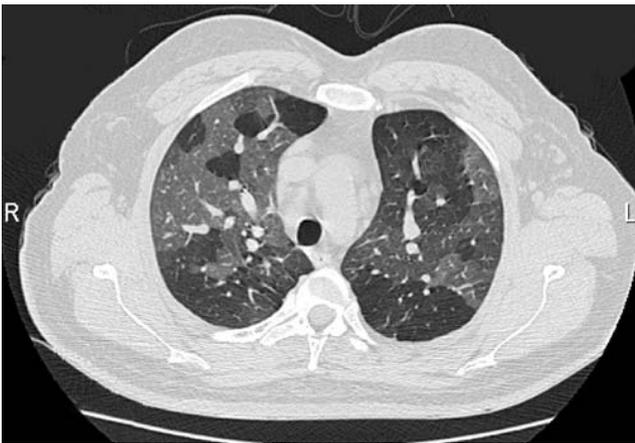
High-resolution computed tomography (HRCT) of a 43-year-old man exposed to mustard gas 20 years earlier. The image demonstrates expiratory air trapping.
